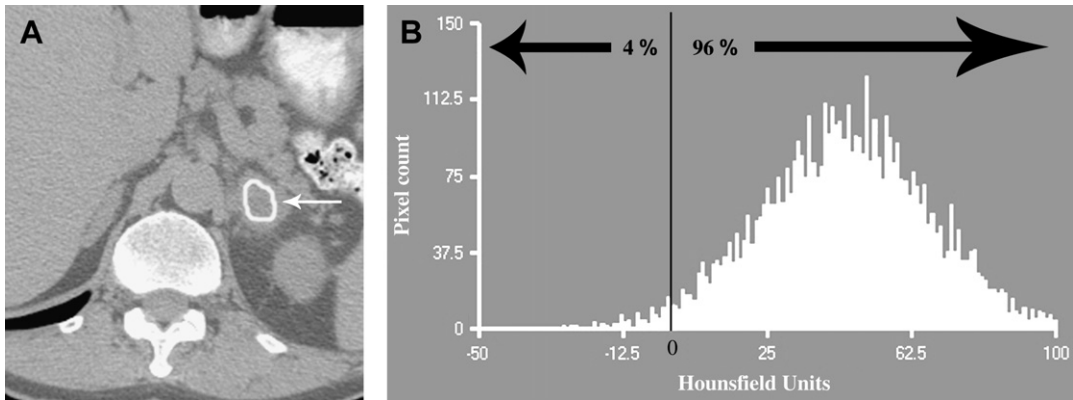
Histogram analysis of adrenal mass. (A) CT scan showing left adrenal lesion with ROI placed within it. (B) Graphic display of distribution of HU values in the mass.
